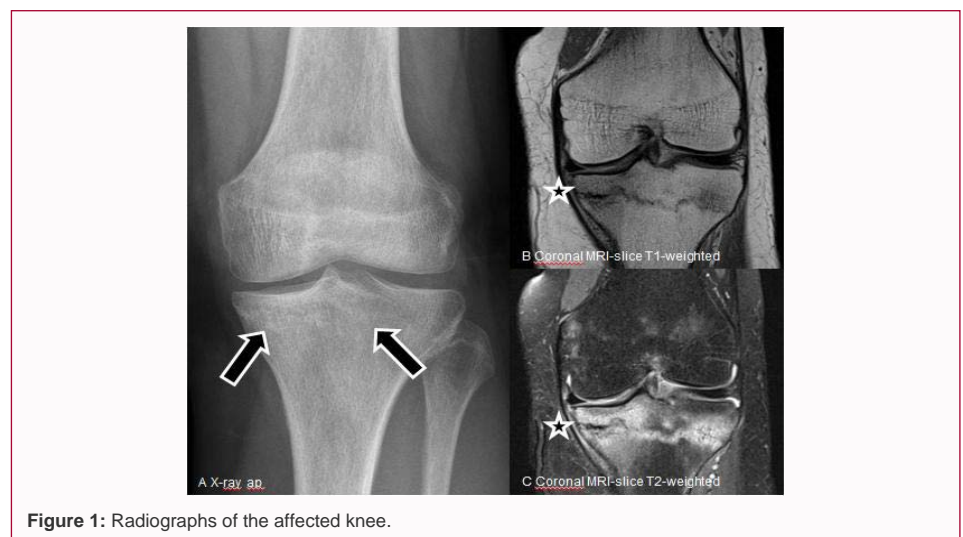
Radiographs of the affected knee.
